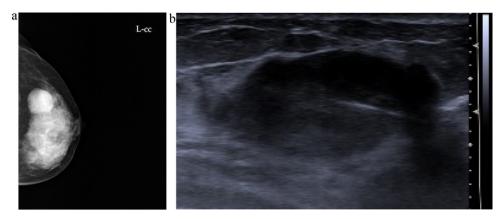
(a and b) BI-RADS category 3. Baseline screening mammogram (left cranio-caudal) (a) and ultrasound (b) of a 51 year old female patient showing a circumscribed, oval, 23 mm in diameter measuring mass, which was prospectively classified as BIRADS III. Ultrasound NBB revealed fibroadenoma, which was confirmed by OSB.
